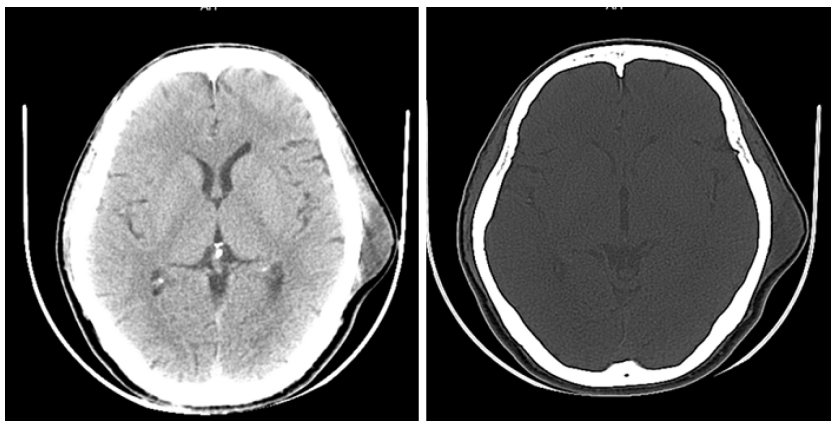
Computed tomography shows a subcutaneous mass in the left temporal region without skull destruction.
